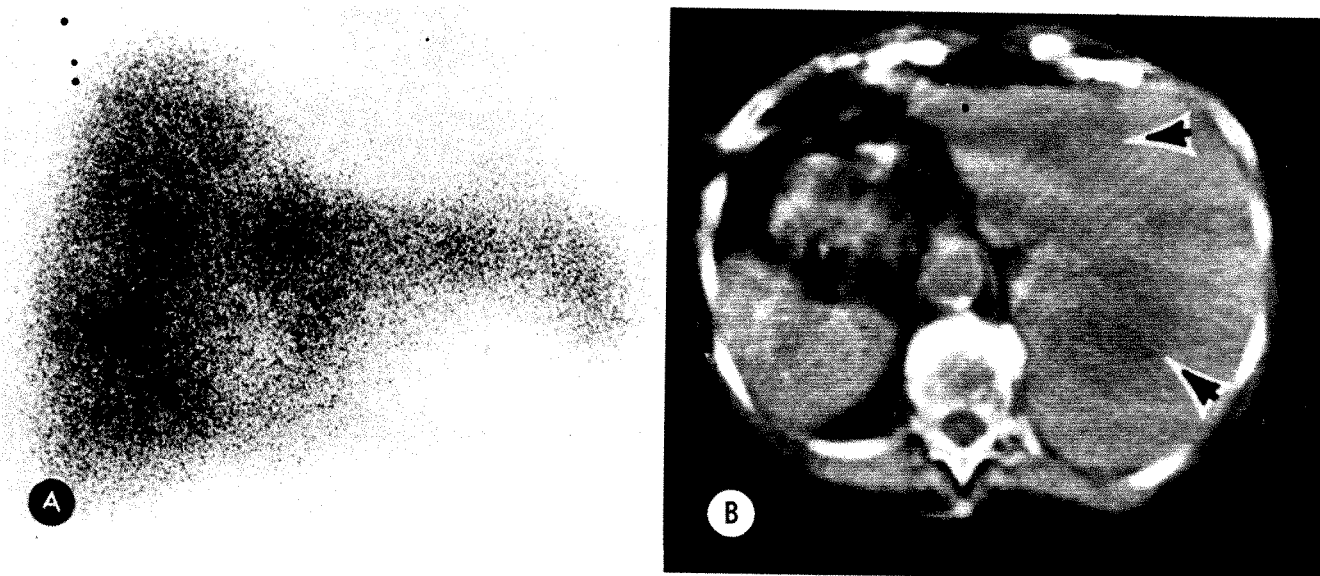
A. Technetium scan of metastases in liver. B. CT scan showing metastases in left and right lobe of liver.
